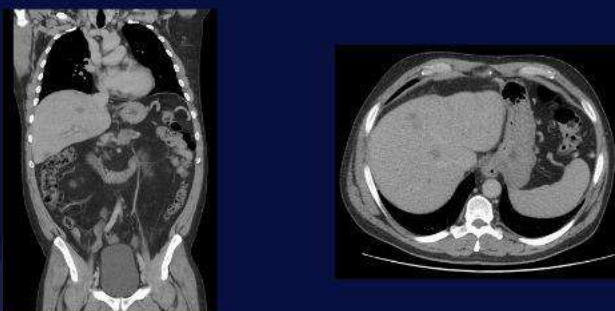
CT Abdomen and Pelvis - metastatic pancreatic cancer
